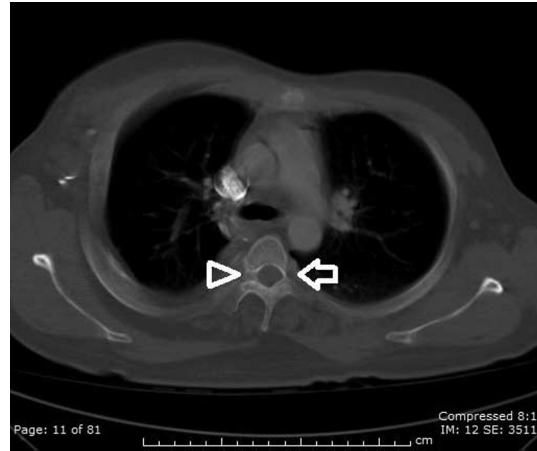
Proteus Syndrome in a 26-year-old male. Axial CT. Note left pedicle hypoplasia (white open arrow) and right pedicle hyperplasia (white open arrowhead) at the 4th vertebral level.
